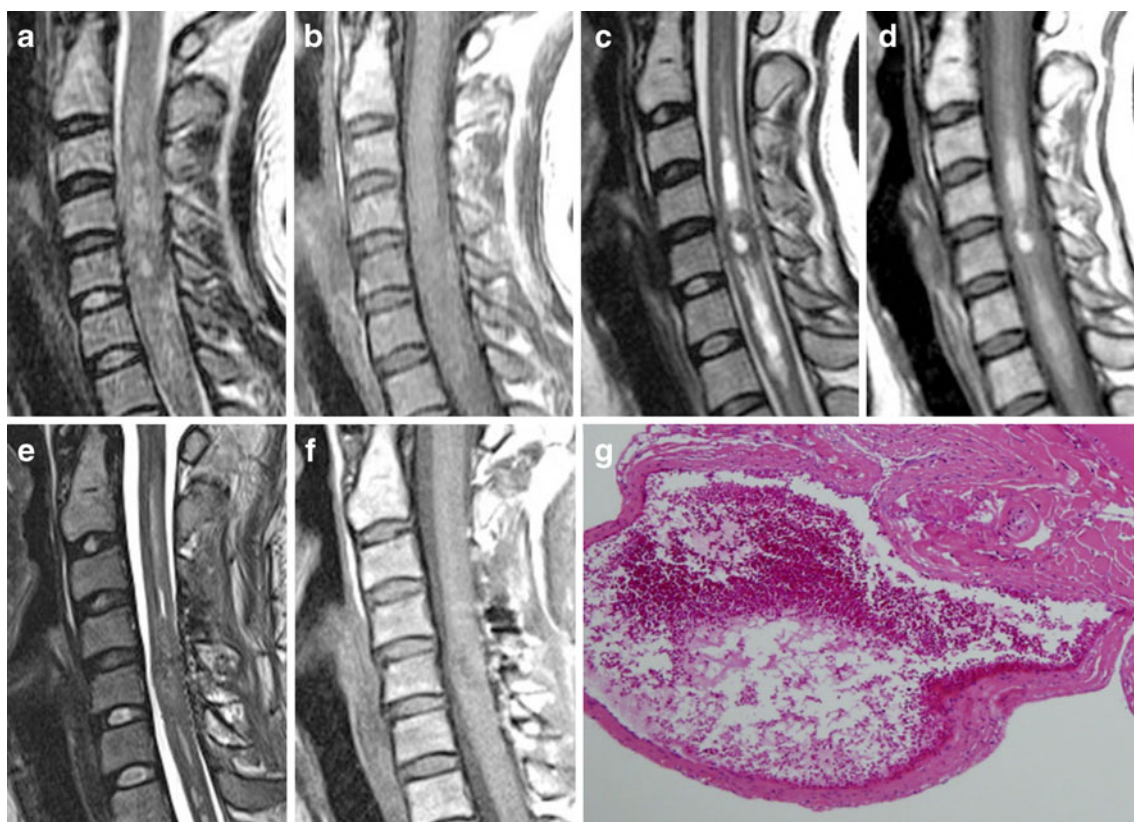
Case 16. CM located at the C5 level. a, b Initial MRI. c, d MRI 3 weeks after admission. e, f Postoperative MRI. g Pathological image. h, i Postoperative plain X ray. a, b Initial MRI showing hematomyelia accompanied by severe cord swelling. c, d MRI 3 weeks after the initial MRI demonstrating resolved cord swelling
